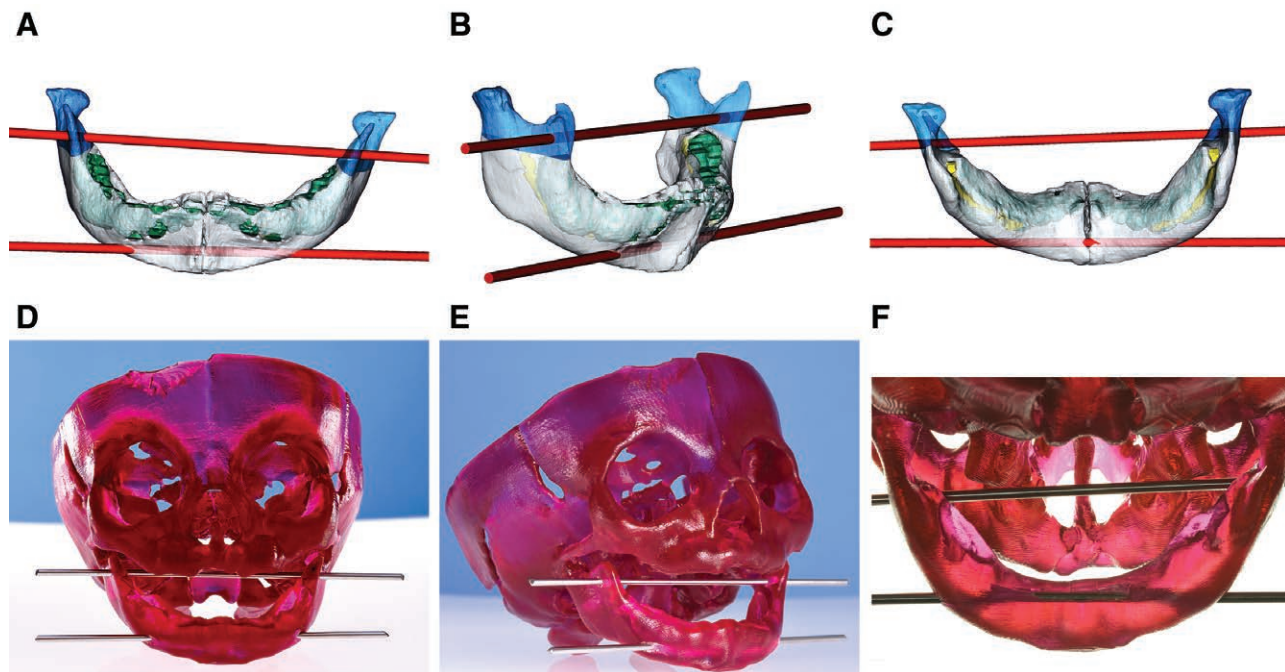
Optimal pin position for the two-pin technique. Segmented CT images (A–C) and photographs (D–F) of a 3D-printed model demonstrating optimal UP and LP position. The UP is placed in the mandibular ascending ramus, within the base of the coronoid process. Care is taken to allow enough room between the pin and the most distal tooth bud for the osteotomy to be performed (along the blue/white junction in A–C). The LP is placed near the lower border of the mandibular body, inferior to all radiologically visible tooth buds, passing through all four mandibular cortices.
